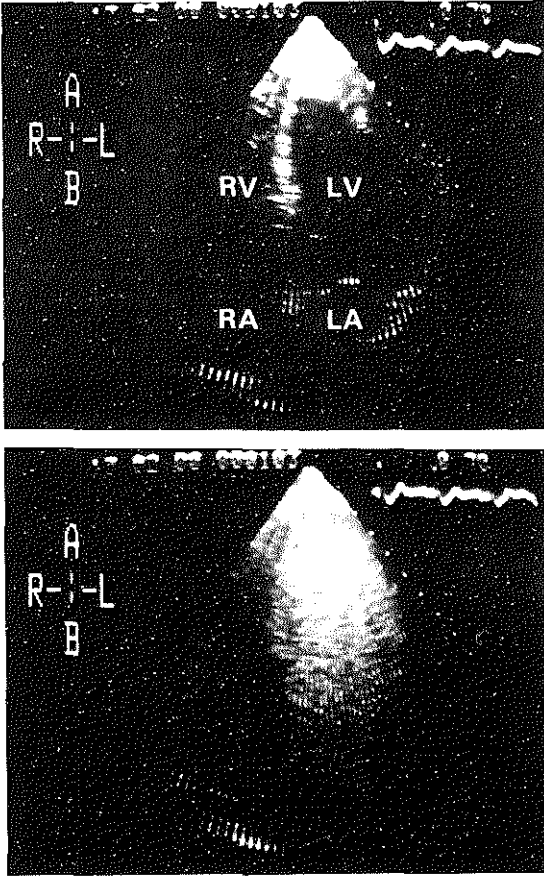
Stop-frame, apical four-chamber views obtained from a patient with a normal left ventricle immediately before (upper panel) and after pulmonary wedge injection of echocontrast (lower panel). The echo contrast fills both the left atrium (LA) and left ventricle (LV), of which the cavity contour becomes clearly delineated.
